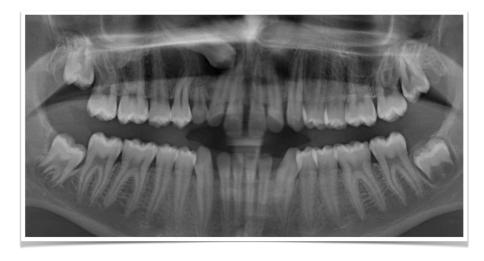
Panoramic x-ray images
